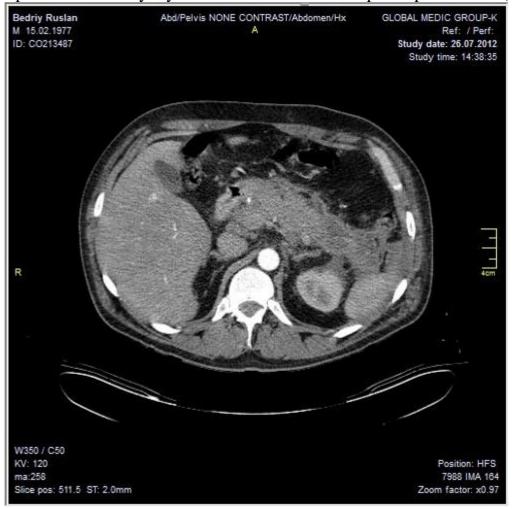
Spiral computed tomography 26.07.12.
